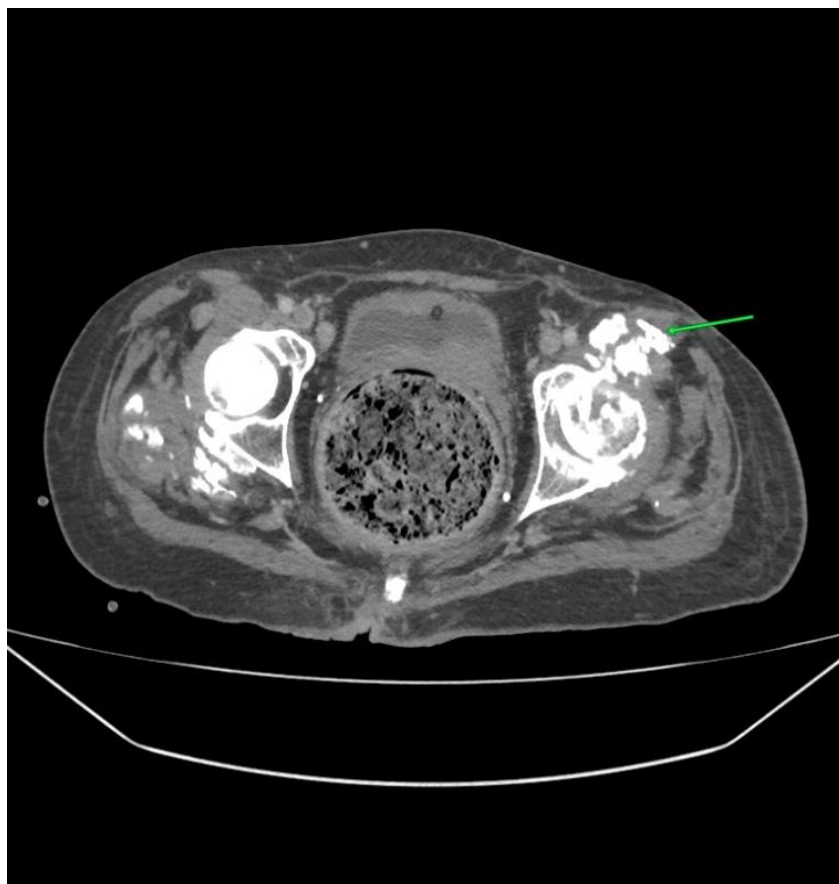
Ossificates around LHJ, CT axial plane.
